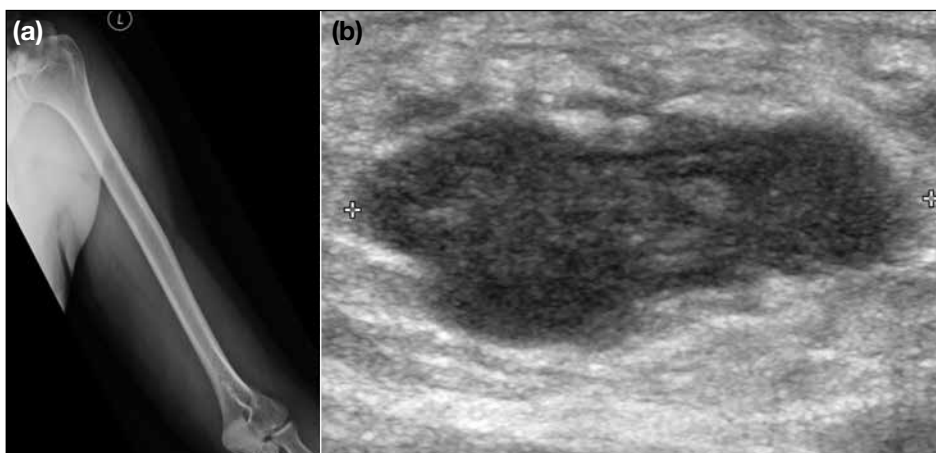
(a) Frontal radiograph in case 2 demonstrated soft tissue swelling at the medial aspect of the left elbow with no calcification or associated bone change. (b) Ultrasound of left elbow in case 2 revealed irregular hypoechoic mass with some internal echoic linear bands.
